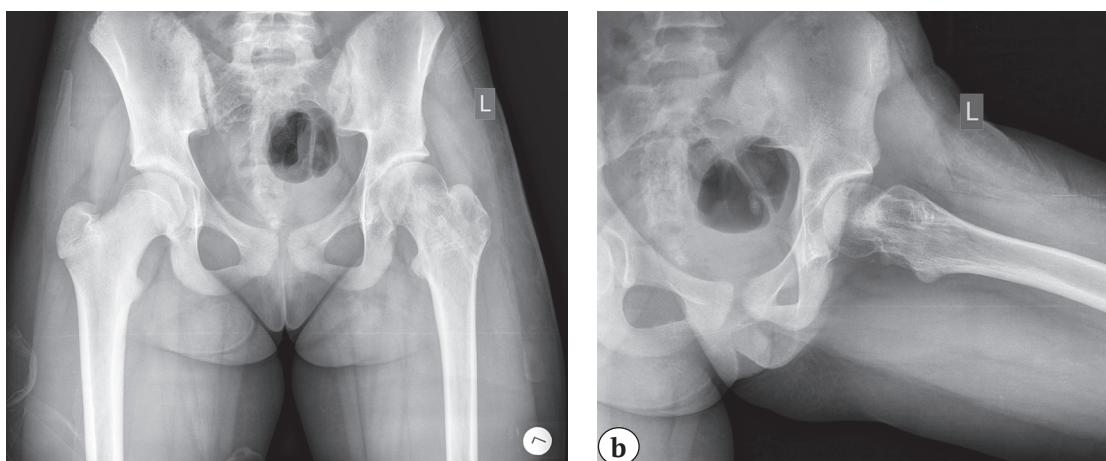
X-rays of hip joint of female patient, 3 years after surgery in AP view (a) and in Lauenstein position (b): correct positioning of femoral epiphysis, no dystrophic changes
